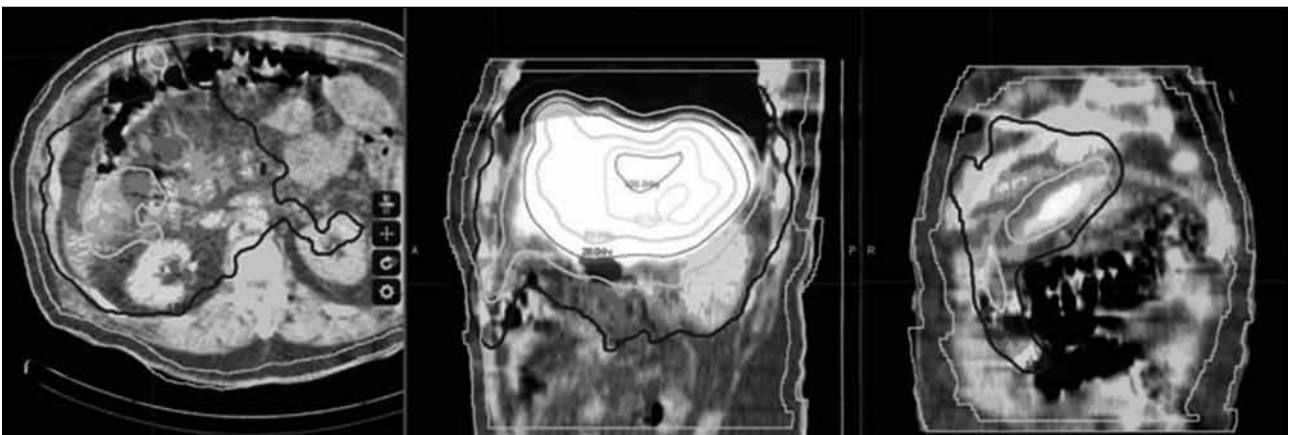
Dose distribution based on macroaggregate albumin single-photon emission computed tomography / computed tomography. The maximum skin dose is 1.8 Gy, and mean dose 0.045 Gy.
